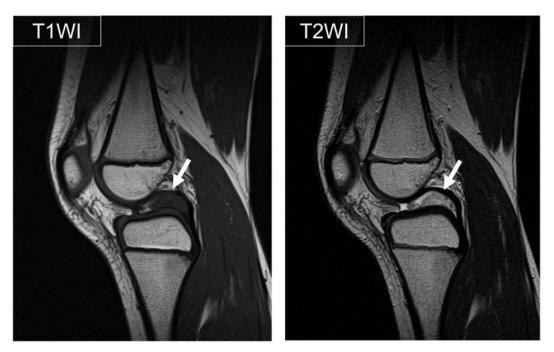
An MR image taken at a first surgery. A mass is located in front of the PCL with low intensity in the T1-weighted image and heterogeneous high intensity in the T2-weighted images.
